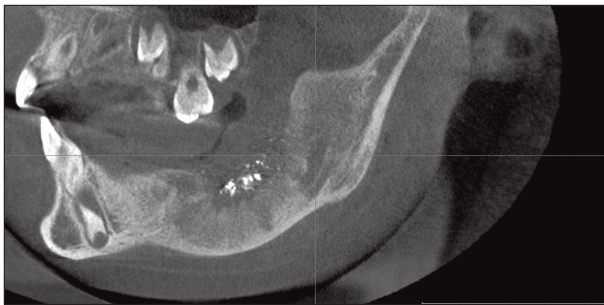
Sagittal section of CT imaging after one year revealing dense bone growth at the site of enucleation.
